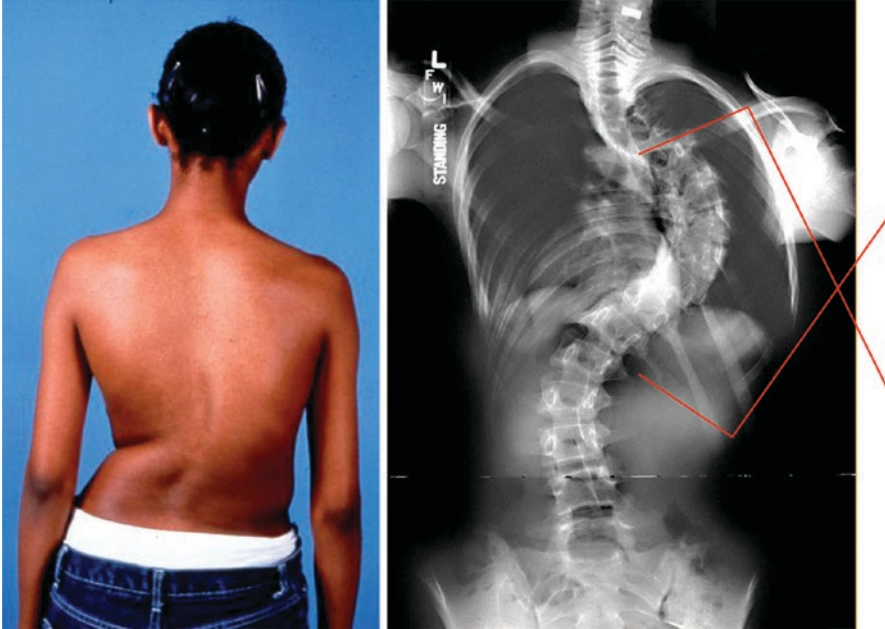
Patient with AIS. Curvature of the spine to the right with shoulder imbalance is evident in the picture on the left. Standing posteroanterior spinal radiograph reveals severe thoracic curvature measuring $>70^\circ$ by the Cobb angle method
